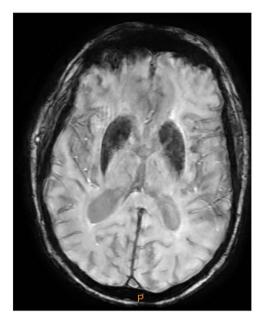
MRI at the level of the basal ganglia: SWI sequencing with signs of mineralization.
